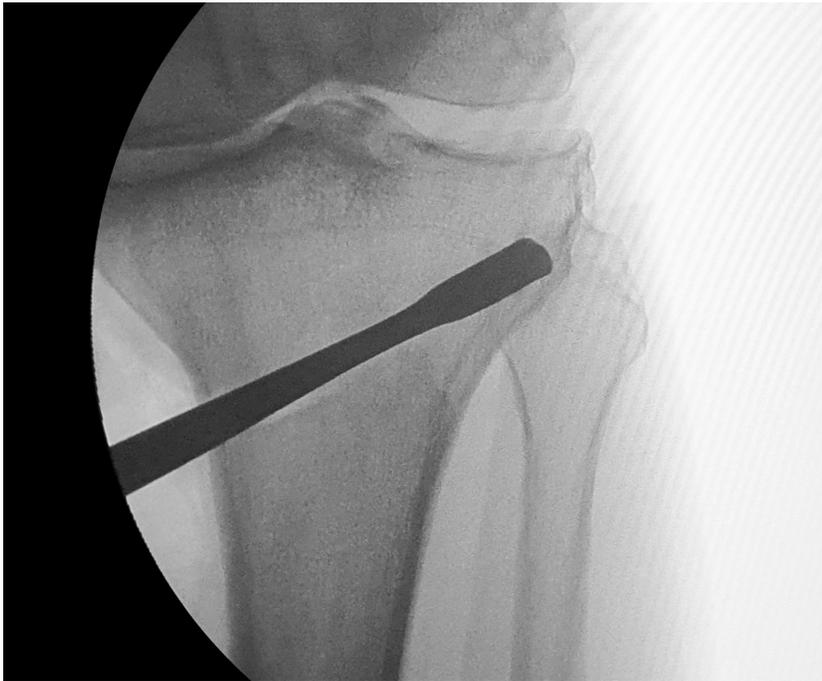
Reference radiographic image for correct osteotome placement at 5mm from the lateral cortex.
